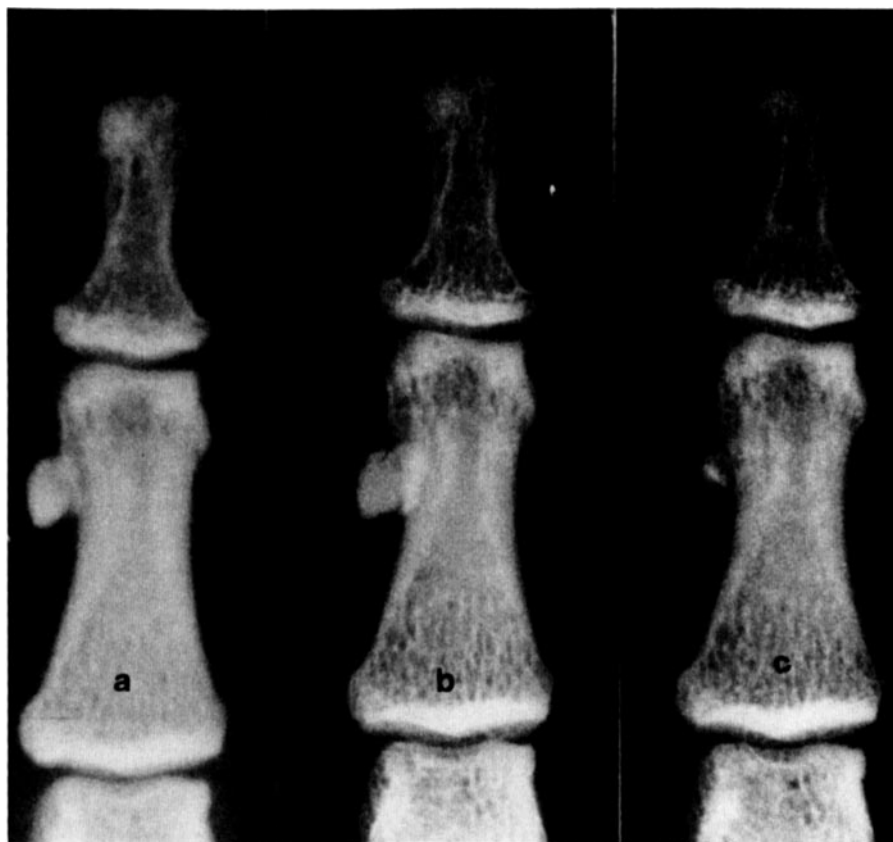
Posteroanterior radiographic view of the patient's left index finger. a, In 1983, there was globular calcification in the soft tissues of the radial side of the middle phalanx, with sclerosis of the lateral aspect of the tip of the distal phalanx and minimal erosion of the tuft. b, In 1984, there was a minimal increase in the size of the soft tissue calcification. c, In 1988, there was a marked decrease in the size of the globular calcification in soft tissues. The terminal phalangeal sclerosis and erosion of the tuft, however, persisted.
